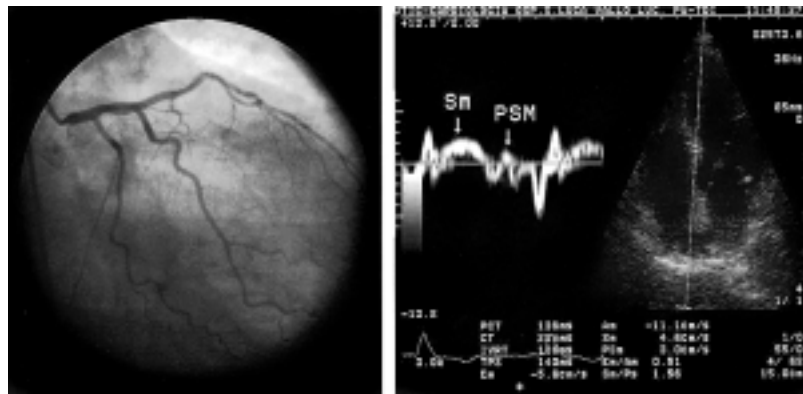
Coronary angiography (left panel) and pulsed tissue Doppler pattern of the posterior septal wall (right panel) in a patient with left bundle branch block but without left anterior descending coronary artery stenosis. The post-systolic motion (PSM) is lower than the myocardial systolic peak velocity (S_m) (S_m/PSM = 1.56).
